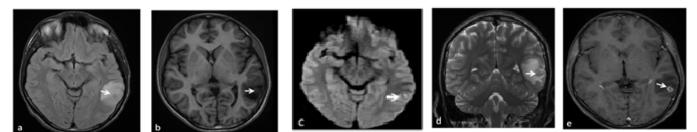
25 yr old male with new onset seizures. Axial T2 FLAIR (a), T1 FLAIR (b) and coronal T2 FRFSE (c) images show left inferior temporal focal edema and a well defined thick walled lesion with T2 hyperintense and T1 hypointense center and T1 hyperintense and T2 hypointense periphery showing central restriction on DWI (c). The lesion shows thick ring enhancement on post contrast T1 image (e). MRI was reported as ?tuberculoma in view of thick enhancing wall and central diffusion restriction. However, CSF antigen for neurocysticercosis were positive and the patient responded to albendazole therapy
